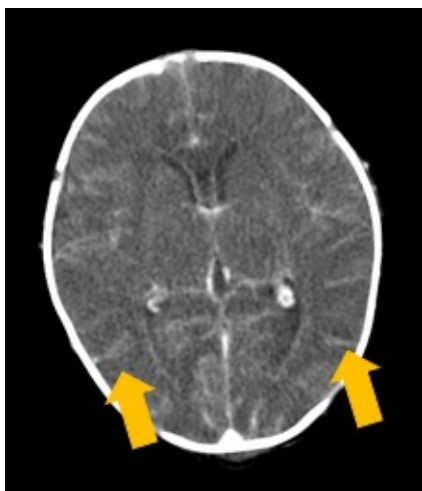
Contrast-enhanced CT brain of a term infant presenting on the day of birth with septic shock, respiratory failure, and leptomeningitis. There is marked cerebral oedema with effacement of the sulcal spaces, while the lateral ventricles demonstrate increased ependymal enhancement and mild dilatation. Increased leptomeningeal enhancement is also noted (arrows).
